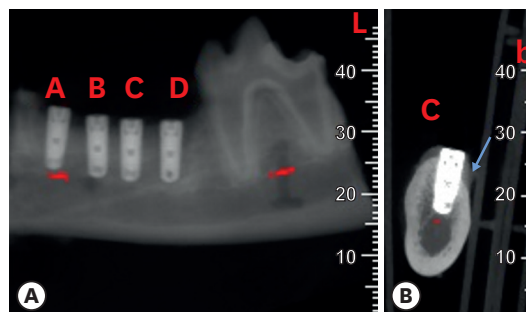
X-ray tomography at 3 months (S100%, intact socket). (A) Mesio-distal view of 4 implants. (B) Linguo-vestibular view of implant B with mineralized bone cortical allograft particles and a membrane. The blue arrow indicates the buccal wall with limited resorption.
